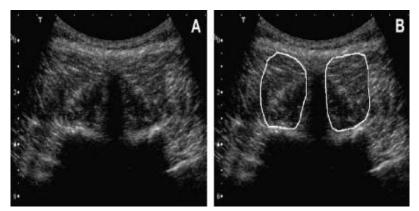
Ultrasonographic images of lumbar multifidus muscle, at rest (A) and contraction (B)
